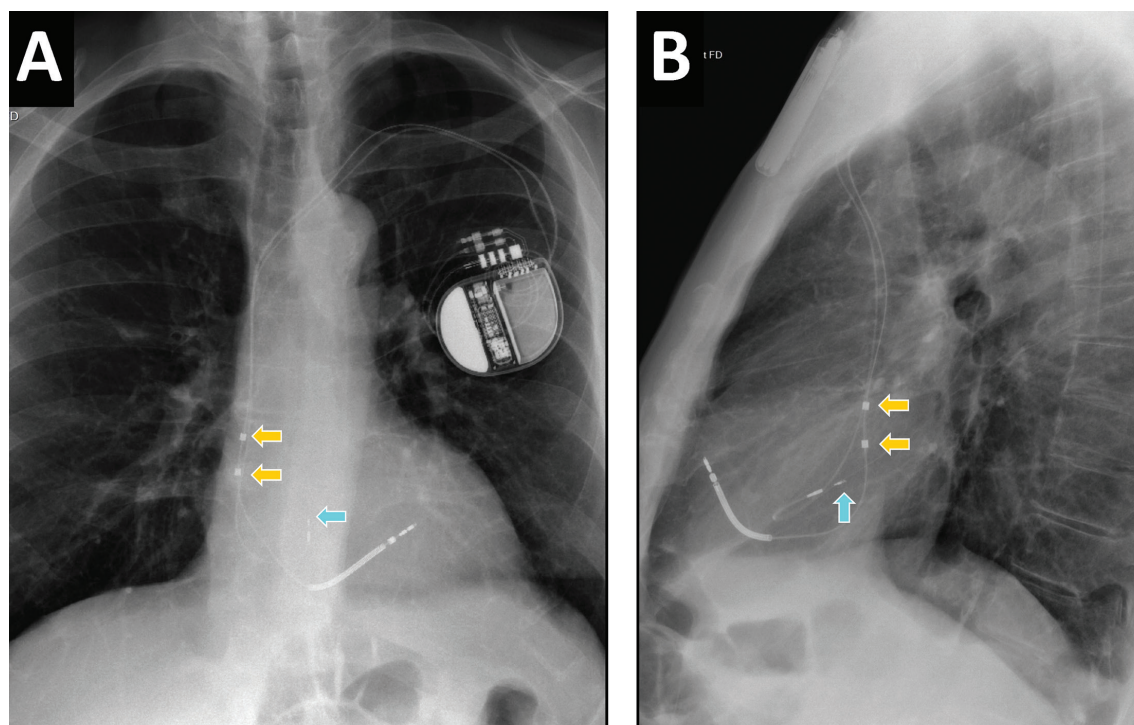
Post-procedure chest x-ray showing the DX system (Biotronik) with SelectSecure (Medtronic) 3830 69-cm His lead, combined using a CRT-D platform. The cardiac silhouette indicates that the floating atrial dipole on the ICD lead (orange arrows) is in the mid-portion of the right atrium (Panel A). The annular position of the 3830 lead (blue arrows) may also be appreciated (Panel B).
